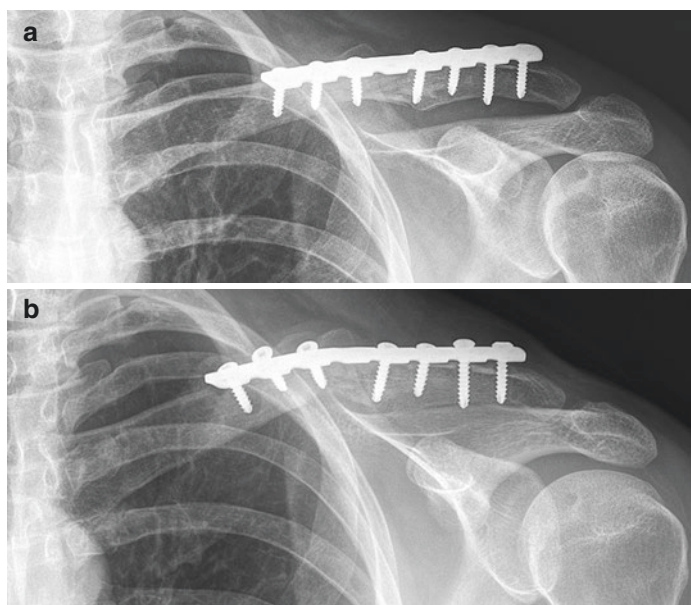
(a) Left clavicle radiograph after initial debridement of open fracture and primary fixation. (b) Left clavicle radiograph 4 months after index procedure demonstrating loosening of fixation and absence of union at fracture site. (c) Left clavicle radiograph after revision open reduction and bone grafting 5 months after index procedure. (bottom) Left clavicle radiograph 6 weeks after revision procedure demonstrating loosening of lateral screws. (d) Left clavicle intraoperative imaging after second revision procedure including hardware removal, soft tissue/osseous debridement, and dual plate fixation. (e) Left clavicle radiographs approximately 6 months after final procedure demonstrating healed fracture
